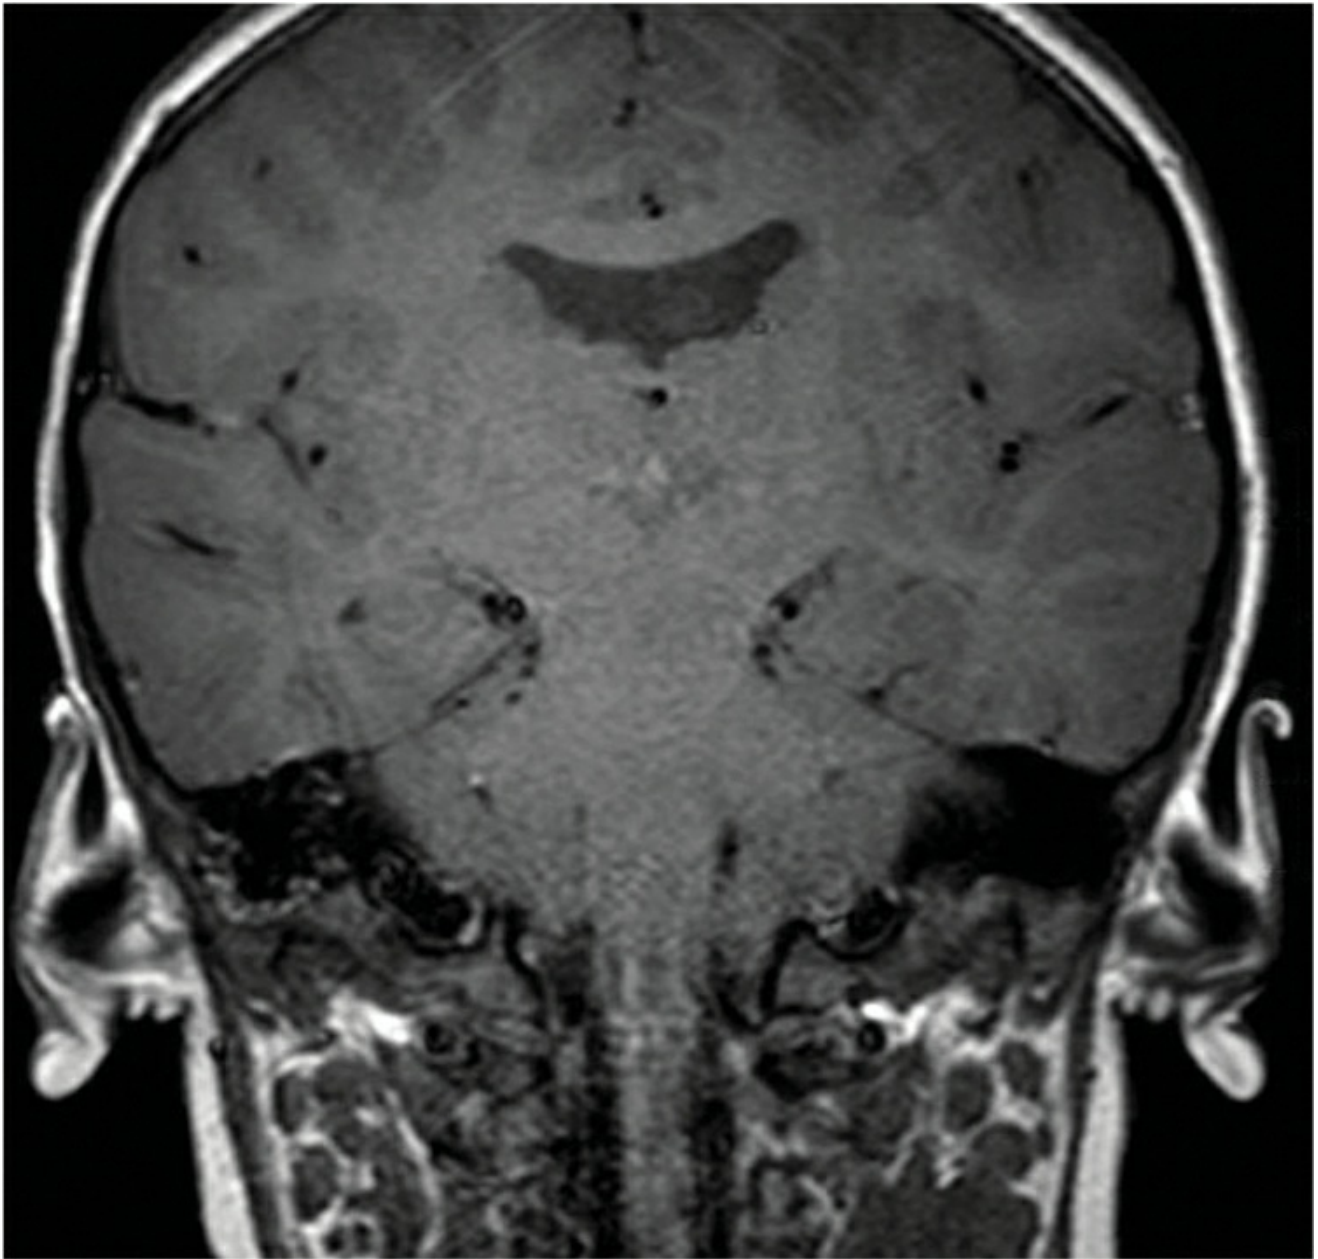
Coronal T1-weighted magnetic resonance imaging (MRI) scan of the lateral ventricles: the septum pellucidum (interventricular septum) is absent. (*Courtesy of Jane L. Weissman, MD.*)
